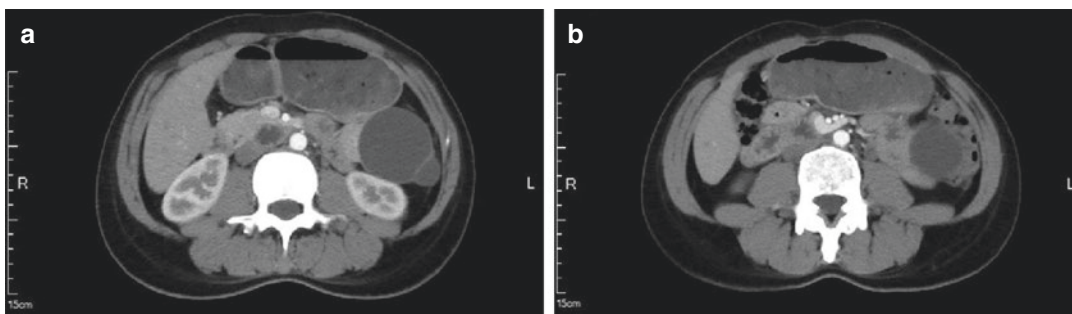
(a, b) CT images showed a mass in the tail of the pancreas
